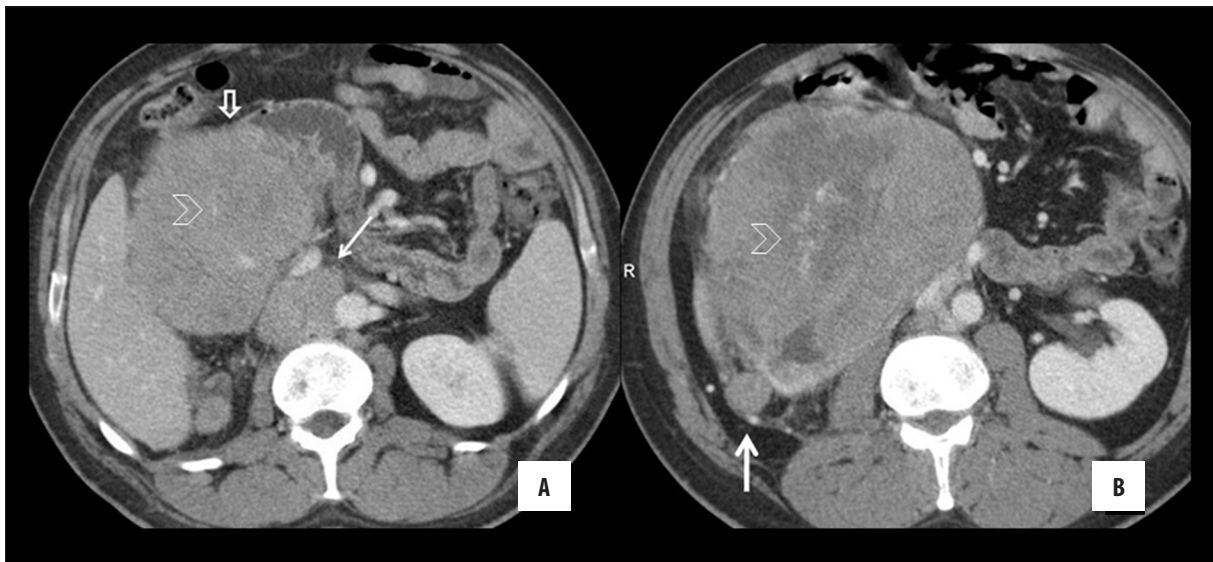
Axial contrast-enhanced CT image (A) reveals a large right-sided renal mass and interaortocaval metastatic lymph nodes (arrow). Note the small bowel invasion (open arrow) which was surgically confirmed. The linear, focal enhancing structures, (arrow heads) represent the internal vasculature of the tumor. The large mass caused severe enlargement and distortion of the right kidney (B) with loss of differentiation of corticomedullary ultrastructure. Note the large tumoral implant (arrow in b) in the Gerota's fascia.
